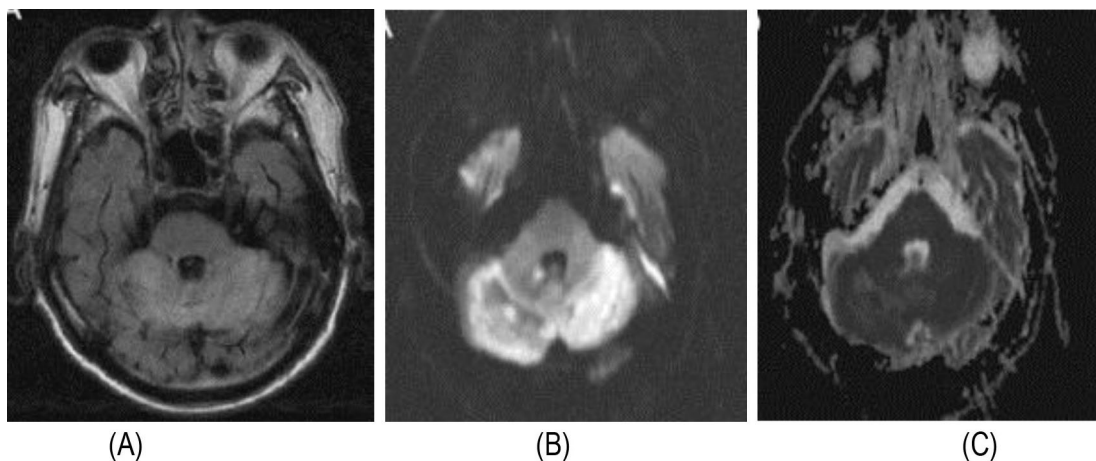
Axial FLAIR image of Wernicke's encephalopathy showing hyperintensity in bilateral cerebellar hemisphere (A), hyperintense on DWI image (B) and hypointense on ADC (C).
